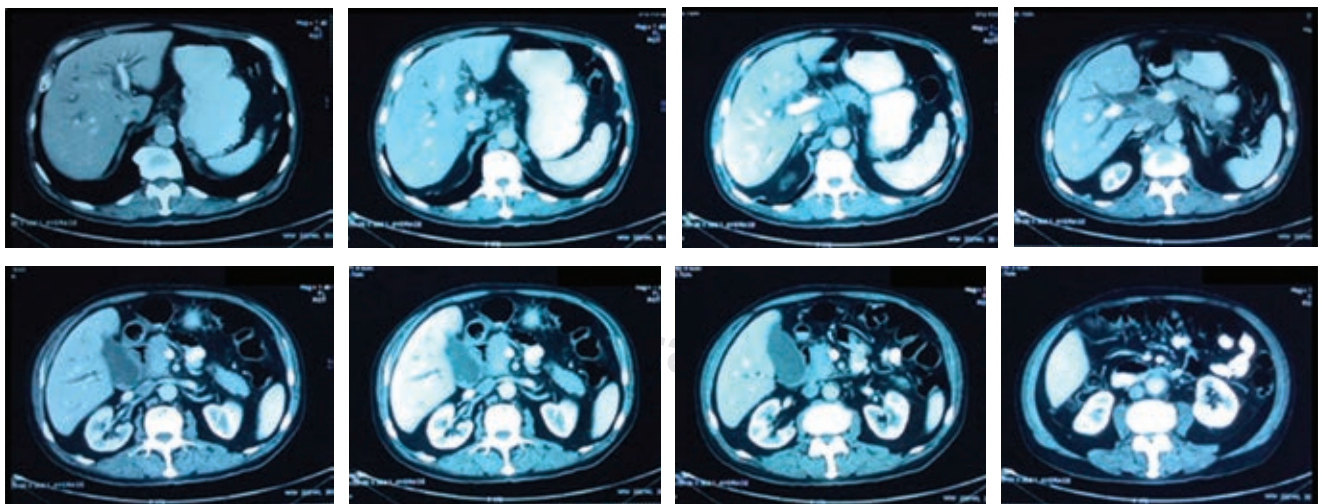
CT scan showing data suggestive of a neoplastic process at the level of the hepatic hilum, which conditions intrahepatic cholestasis, and may correspond to a Klatskin's tumor without being able to rule out an inflammatory process.
